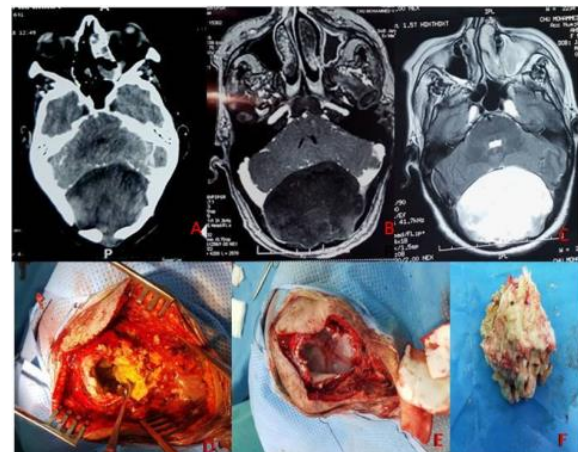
A. Preoperative computed tomographic (CT) scans show giant infratentorial extracerebellar hypodense lesion with extensive occipital bone destruction and substantial mass effect in the posterior cranial fossa. B. Preoperative magnetic resonance (MR) images show giant infratentorial extradural intradiploic tumour, inhomogeneously hypointense in T1-weighted images post gadolinium and hyperintense in T2-weighted. C. Intraoperative photos. D,E,F. where the lesion characteristic and the significant erosion of the occipital bone is observed.
